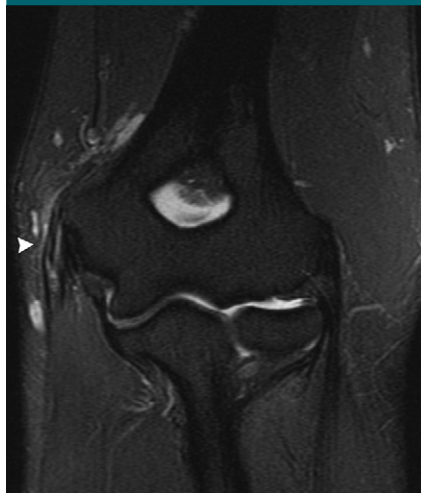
Coronal T2-weighted FS MR image in a 42-year-old man with medial epicondylitis demonstrates linear high T2 signal intensity in the common flexor tendon (arrowhead), with edema in the adjacent soft tissues.
